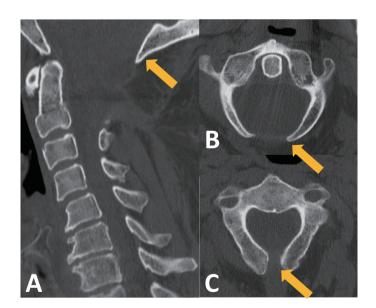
A preoperative cervical spine CT reveals spina bifida in C1 (axial image; B; arrow) and C2 (axial image; C; arrow) laminae, which look like congenital anomaly given the configuration.
